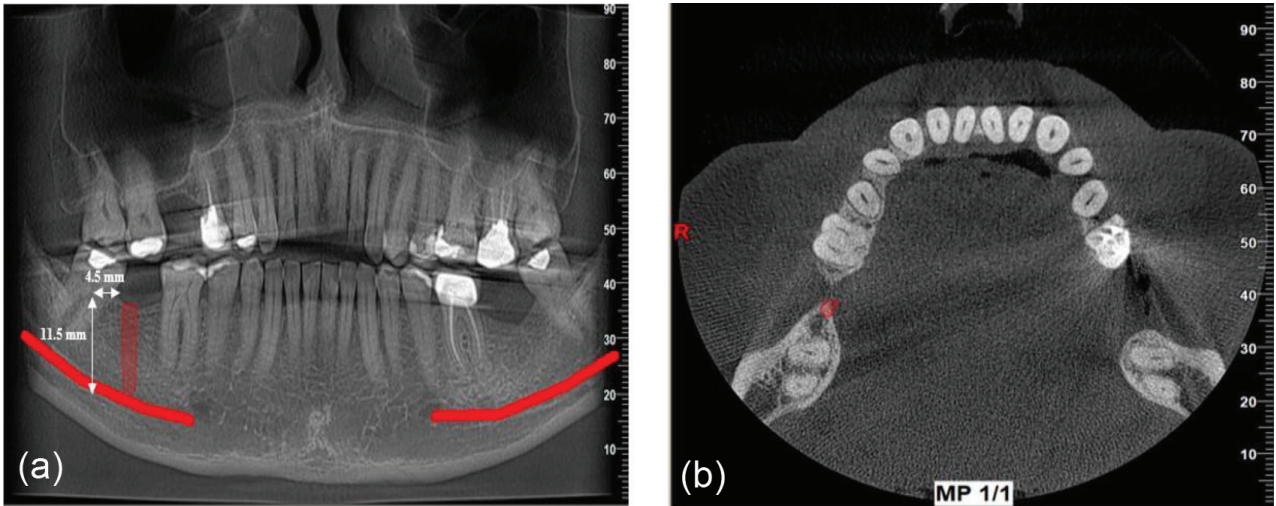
CBCT scan of a patient with a missing tooth in D4 bone
